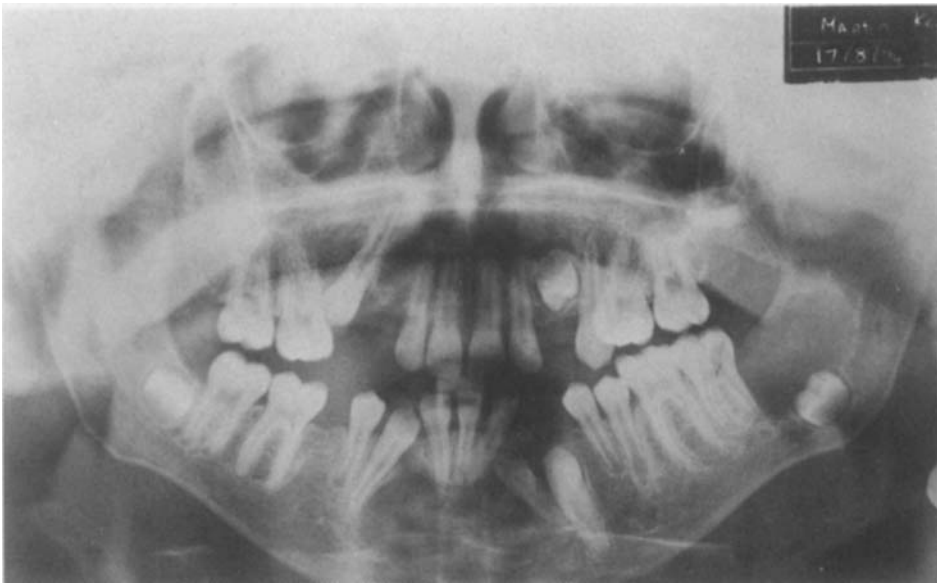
Orthopantomograph (radiographic view) taken approximately eight months later, showing significant enlargement of the odontogenic keratocyst in the mandibular left third molar region with gross displacement of this tooth.
